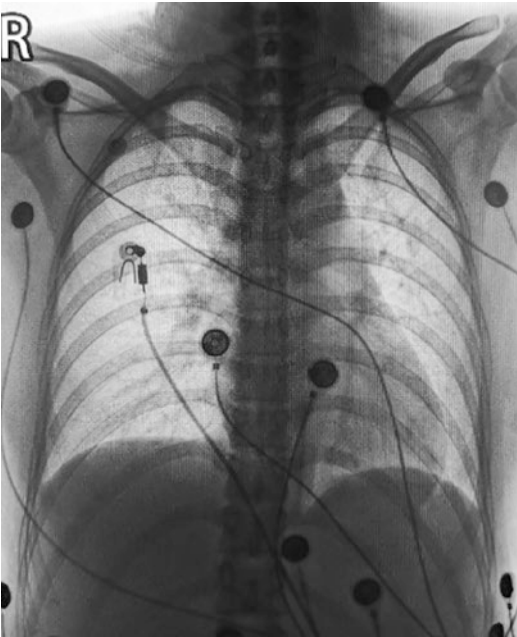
Chest radiograph on the first day after admission: enhanced lung texture
